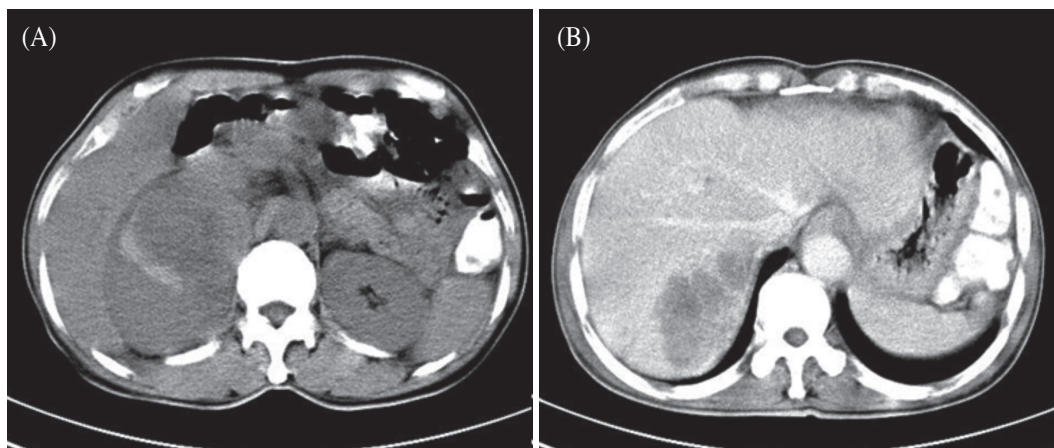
(A) Cotrast enhanced CT shows ill-defined inhomogeneous lesion in the right adrenal gland. (B) Delayed phase CT shows irregular heterogeneous low-attenuated mass in hepatic segment 6.
